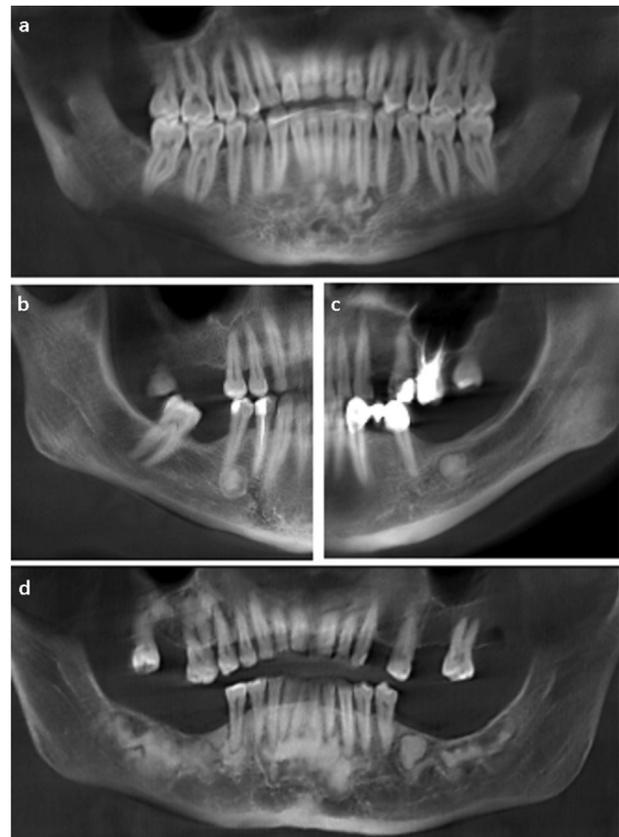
Panoramic reconstruction cone beam computed tomography images of a. periapical, b. focal (single posterior tooth), c. focal (single posterior edentulous alveolar crest), and d. florid cemento-osseous dysplasia cases.
